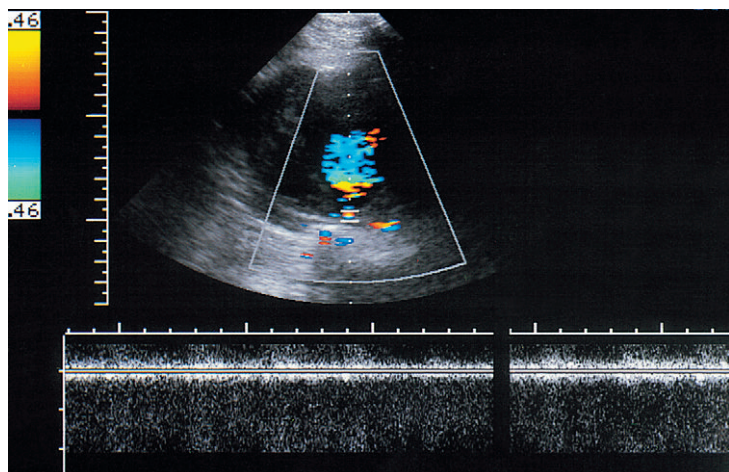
Colour Doppler image of an aortocaval fistula in a patient with an aneurysm. The spectral Doppler gate is on the fistula and the spectral display shows a turbulent signal which is largely off the spectral range at these settings.
